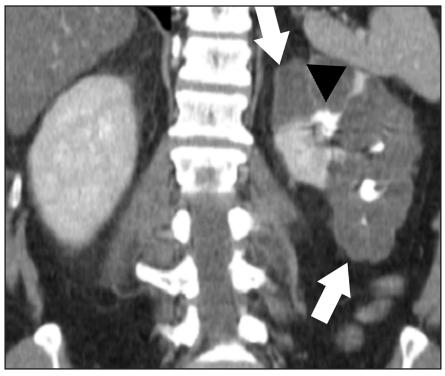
Localized cystic kidney disease (LCKD) in a 36-year-old man. Coronal contrastenhanced CT image shows multiple cysts, almost involving the entire left renal parenchyma however, there is normal contrast excretion into the collecting system (arrowheads) consistent with localized cystic kidney disease. These cysts were unchanged in appearance for prior 10 years.
